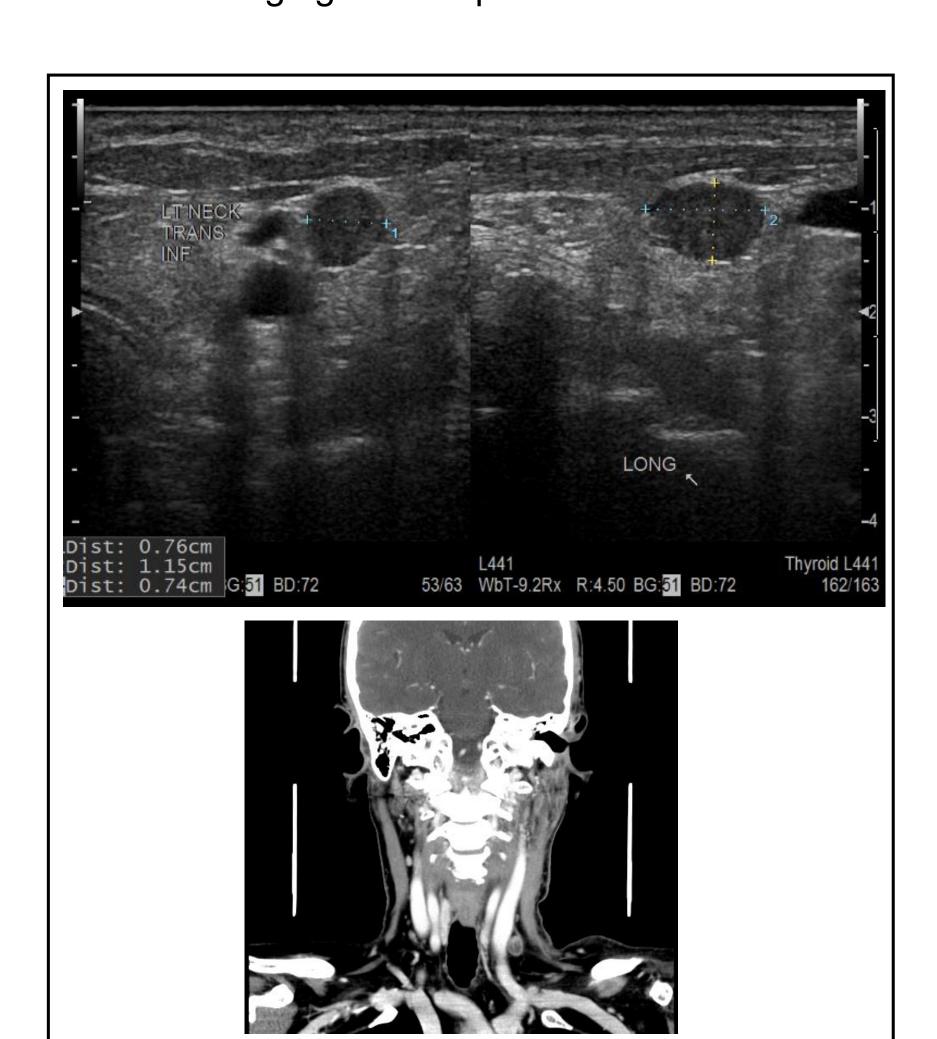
The top image shows a left lateral neck diagnostic ultrasound depicting a
